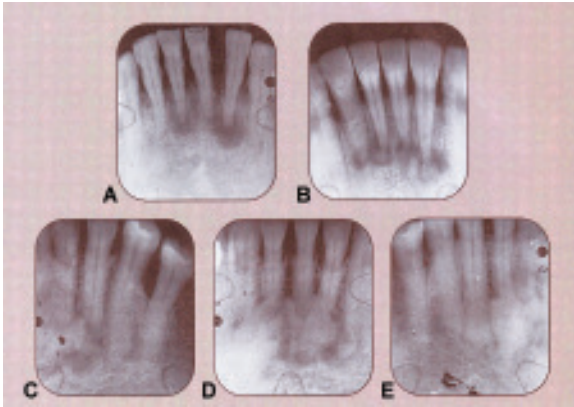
Showing radiographic course of periapical cemento-osseous dysplasia in series of periapical radiographs: (A) beginning radiolucencing; (B) and (C) beginning and more mature radiopacities creating a more dense, irregular, mixed radiolucent-radiopaque appearance; (D) and (E) mature radiopacities creating a pure, well-outlined radiopaque appearance
